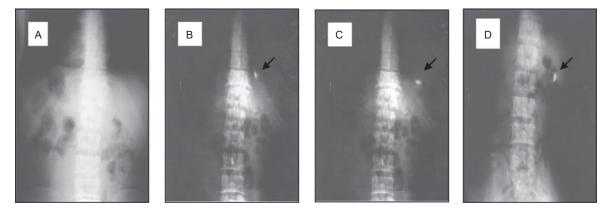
X-ray photographing of floating tablet at 0 h (A), 1 h (B), 3 h (C), and 5 h (D).
